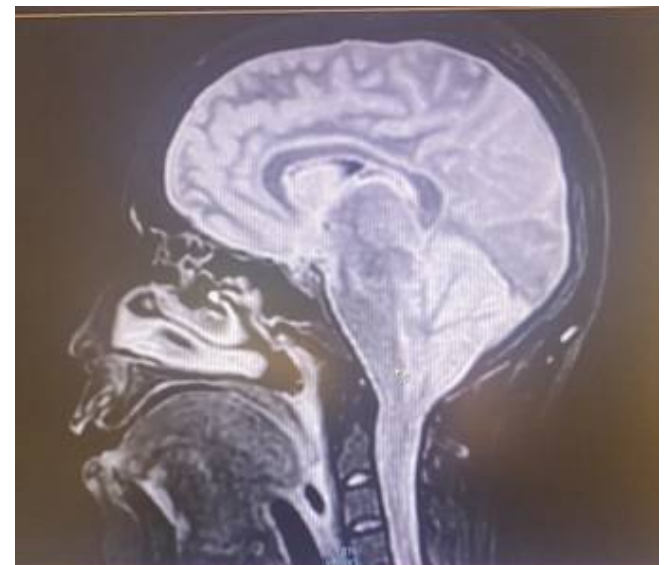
Sagittal FLAIR image shows tonsillar herniation, effacement of visualized sulci and cisterns and diffuse high signal intensity in cerebral and cerebellar cortex consistent with diffuse brain oedema.
